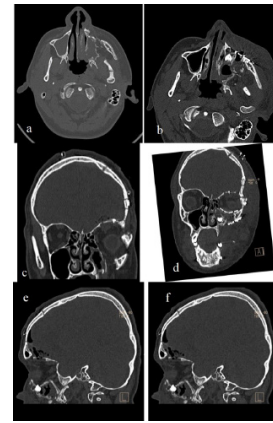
Post operative clinical appearance of corrected malar projection and eyelid fullness and pre-op and post-op CT scan cuts comparison. a and b) axial view show anterior maxillary sinus wall changes. c and d) coronal view. e and f) sagittal view, the orbital floor alignment has reached quite as far as the orbital apex.
